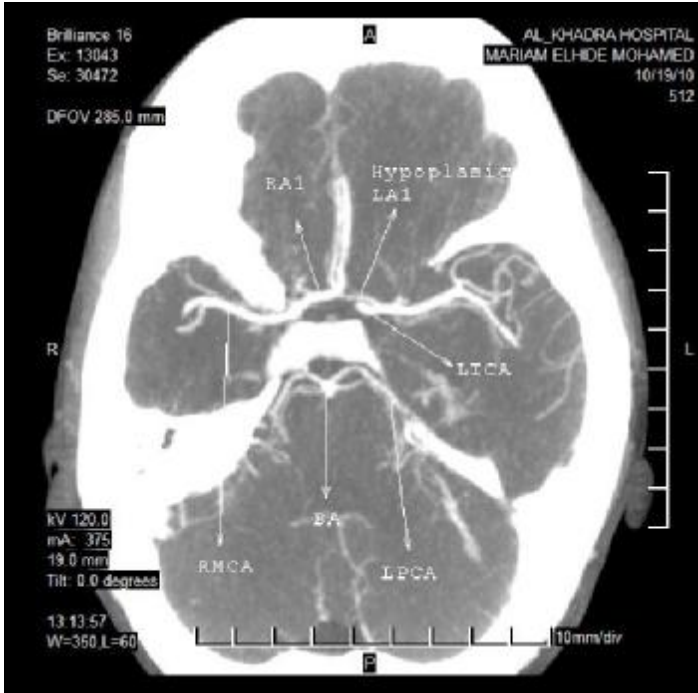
CTA shows hypoplastic LA1 and bilateral missing of PcomA.
